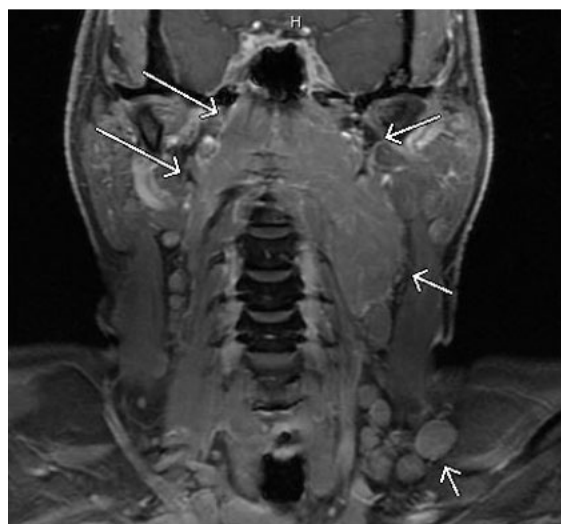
Preoperative coronal CT image of cervical spine demonstrating soft tissue mass.
